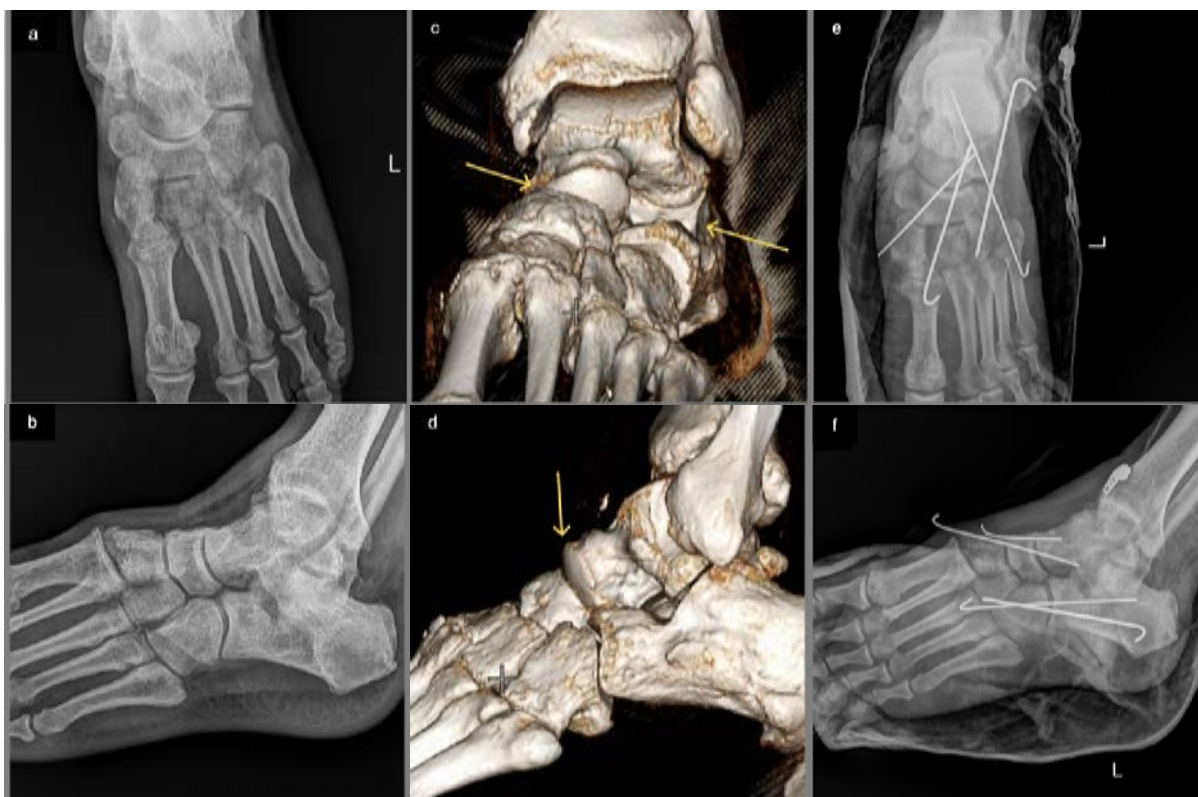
Imaging diagnostics of Case 1 patient: plain X-rays did not show definitive radiological signs of injury (a, b); three-dimensional computed tomography showed dislocation in the Chopart joint (yellow arrows) (c, d); postoperative X-rays, with transfixion of talonavicular and calcaneocuboid joints, show the congruence of these joints (white lines indicate K-wires) (e, f).
